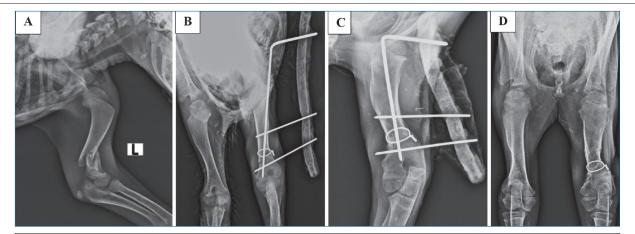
A- Preoperative radiograph of a case of distal diaphyseal short oblique humeral fracture, B- Immediate postoperative radiograph, C-Radiograph on postoperative day 35, D- Radiograph on day 35 after the removal of the postoperative tie-in components
